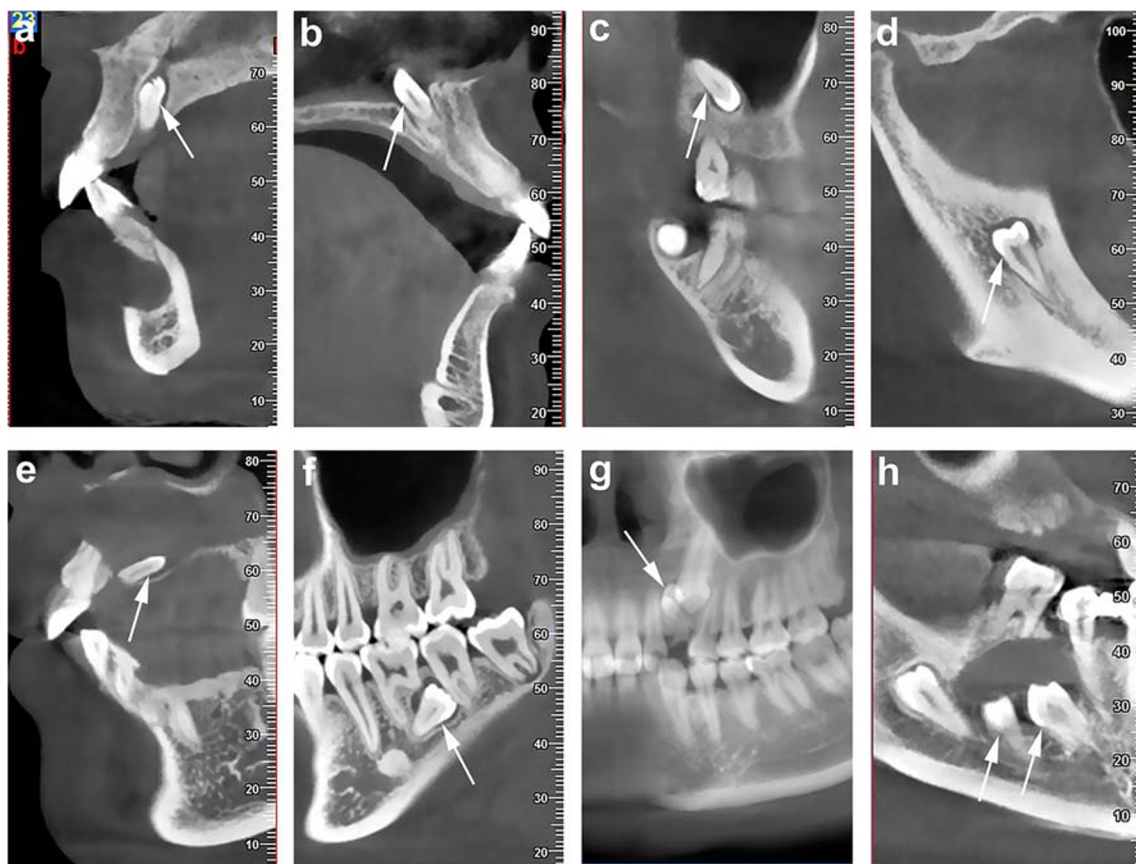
Representative CBCT images exhibiting relationship of ST with neighboring structures and their associated complications. a ST located in nasopalatine canal; b ST penetrated into nasal floor; c ST located in maxillary sinus; d ST located within mandibular ramus; e ST-associated cystic lesions in maxilla; f ST-associated root resorption of adjacent tooth
